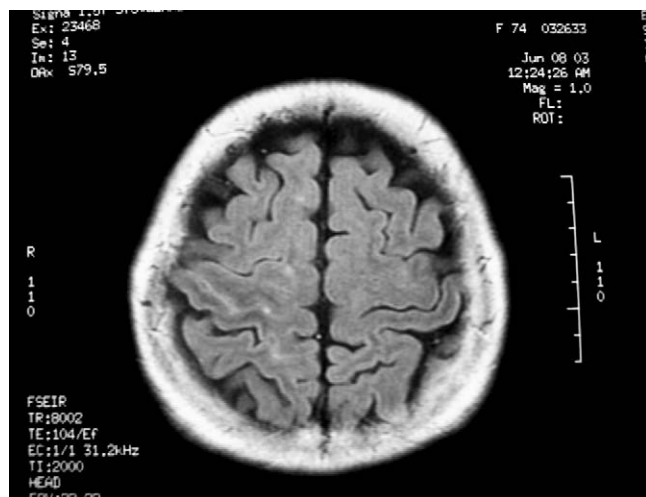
Case patient 1: A restricted SAH in the right frontal lobe was observed on MRI.
